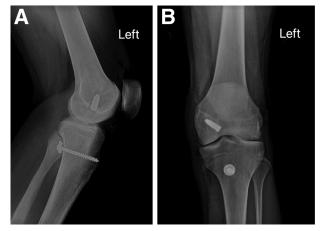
(A and B) Lateral- and anteroposterior-view radiographs with the postoperative treatment with the Paccola's technique, noting the tibial cancellous screw's positioning more distal than PCL footprint. (PCL, posterior cruciate ligament.)
